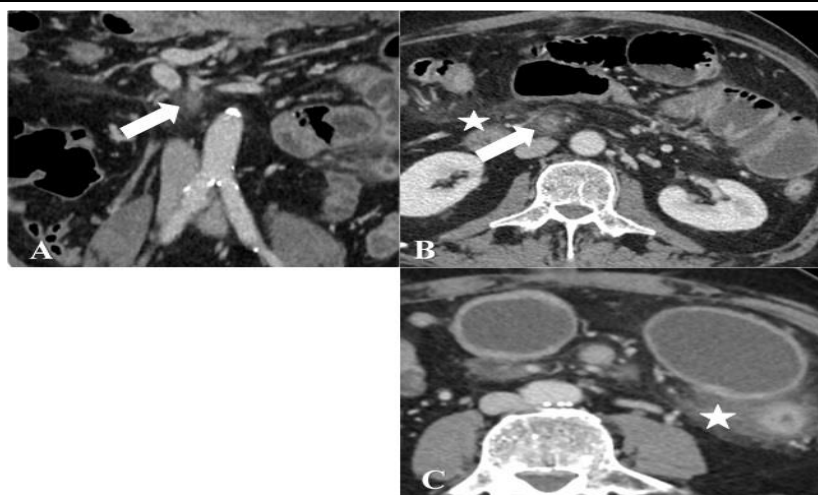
Bowel ischemia as a complication of COVID-19 in a 60-year-old man (A-C) coronal (A) and axial (B, C) intravenous contrast material-enhanced CT images of the abdomen and pelvis show intraluminal filling defect of thrombosis involving the superior mesenteric shortly after its origin, its jejunal branches (arrow) with small bowel dilatation with special stranding of the related fat panes, as well as mesenteric root (star).
